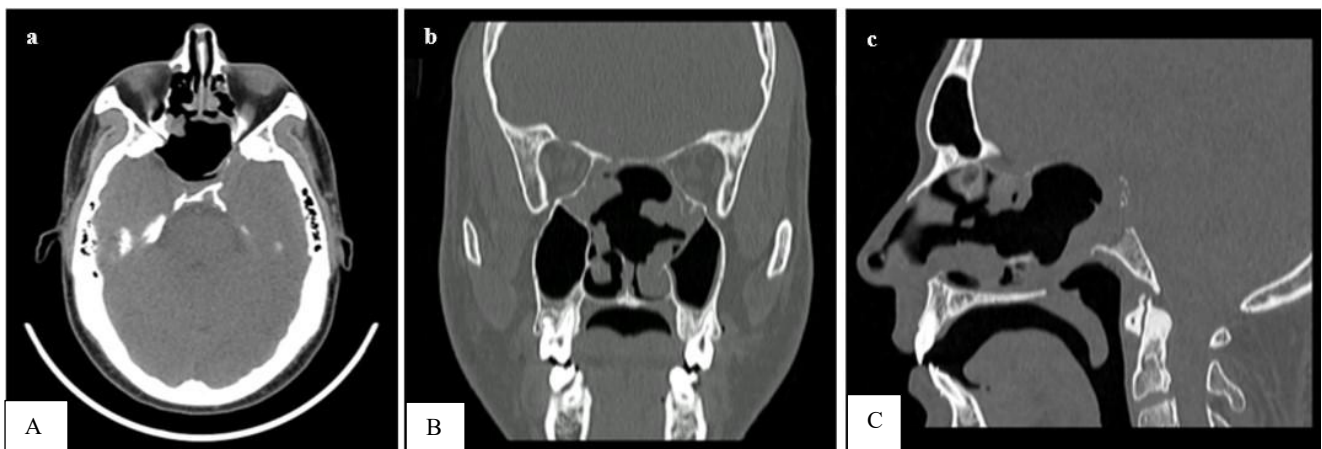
Postoperative computed tomography at 72 hours confirming subtotal lesion resection: (A) axial plane, (B) coronal plane and (C) sagittal plane.
